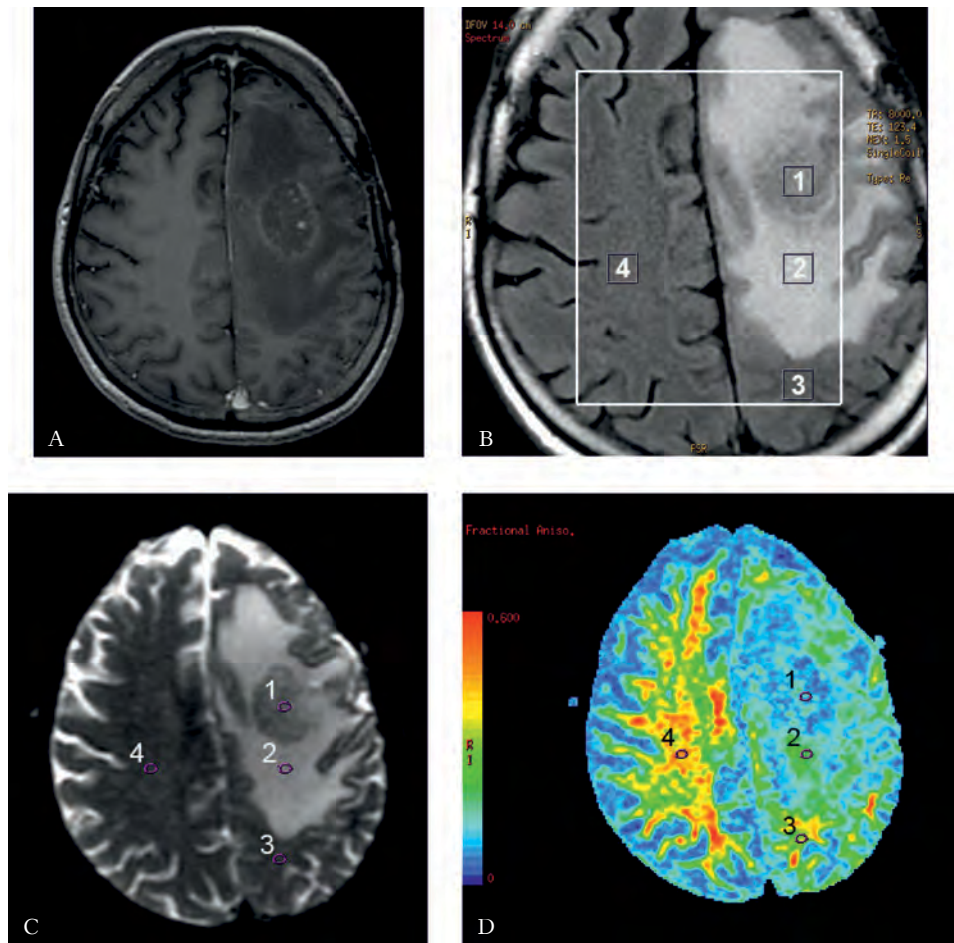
MR images of a 48-year-old male with a recurrent anaplastic oligodendroglioma in the left frontal lobe
